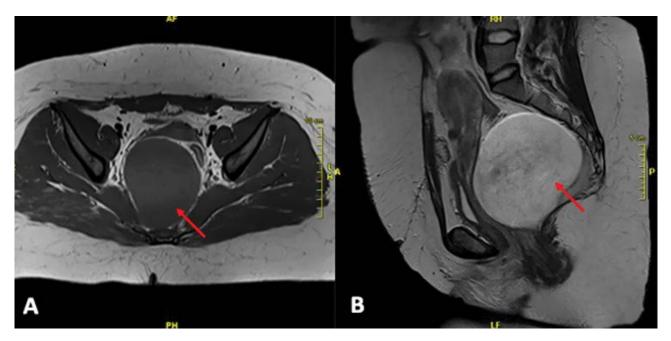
A. MRI in the axial plane, voluminous structure in the pelvis. B. MRI in the sagittal plane, voluminous structure in the pelvis (indicated by an arrow).
